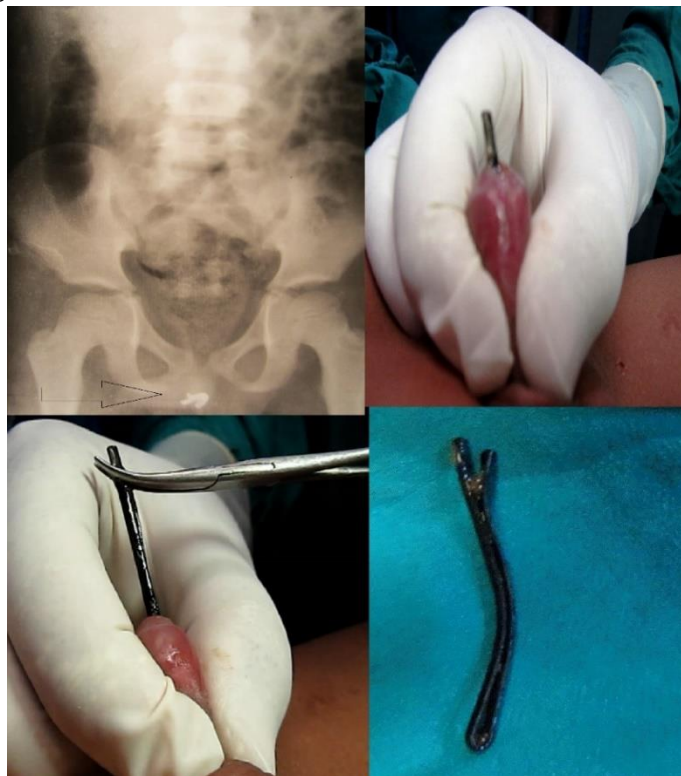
X-ray and operative pictures of a long slender urethral foreign body in a 5-years old male child.
